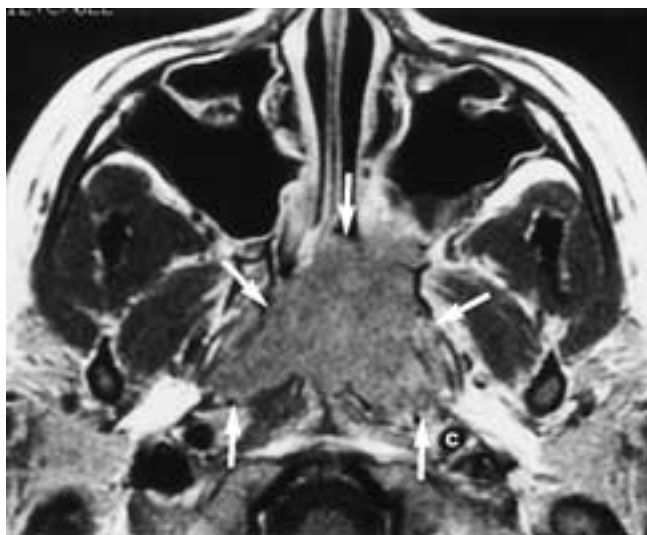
Axial T1-weighted, contrast-enhanced MR image better demonstrates the full extent of this lymphoepithelioma (*arrows*). Note the proximity of the tumor to the left carotid artery (*C*).
